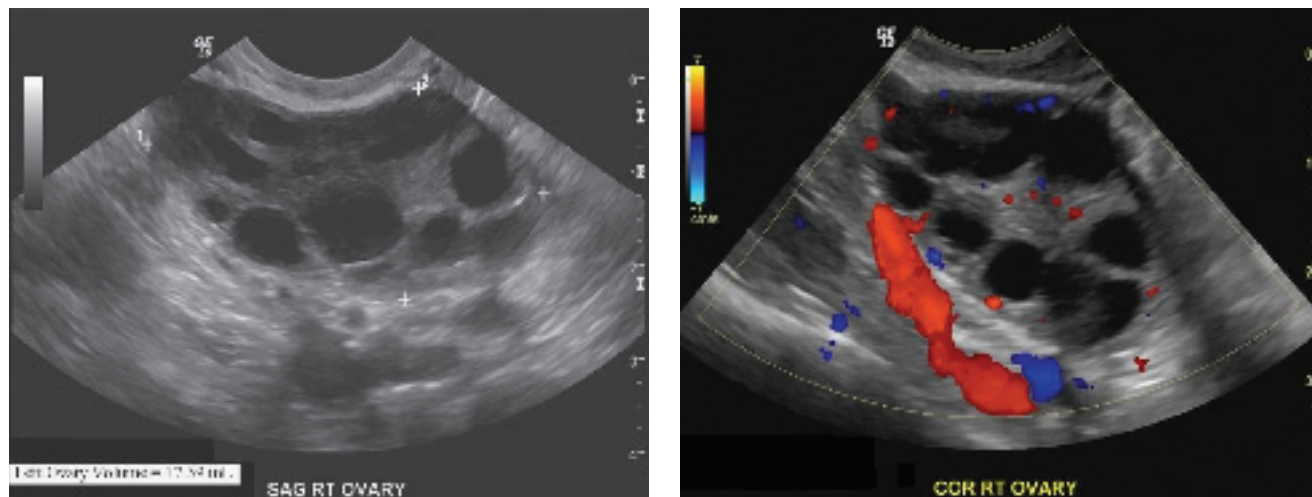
(A) Sagittal gray scale and (B) color sonographic images through the left ovary demonstrate an enlarged ovary with multiple peripheral follicles. Flow is demonstrated within the ovary. Arterial and venous waveforms (not shown) were normal.
